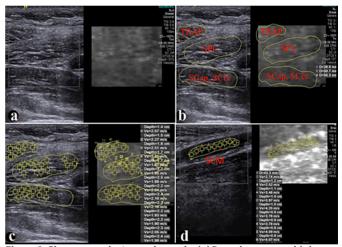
Shear wave elastography mode. (a) B-mode sonographic image of the upper TRAP, middle SPLC, and lower SCC. (b) Marking of the sample area. (c) Boxes showing elastographic measurements within these areas. (d) Marking and measurement of the sternocleidomastoid (SCM) sample area.
